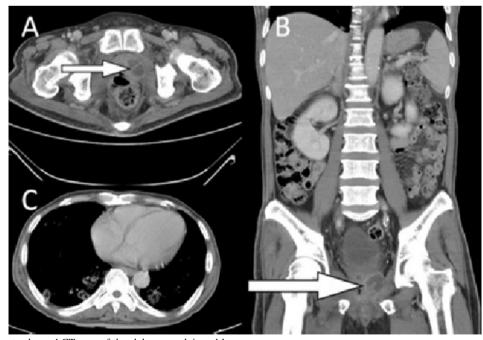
The contrast-enhanced CT scan of the abdomen, pelvis and lung. The axial view demonstrated that lobulated lesion of heterogeneous hypodensity (arrow in A). The coronal view demonstrated lobulated lesion of heterogeneous hypodensity (arrow in B) and no focal lesions within the parenchyma of liver, spleen, kidney and iliopsoas muscle. The axial view of CT scan the lung depicted multiple ring-enhanced lesions near bilateral pleural base with central cavitations consistent with septic pulmonary emboli complicating lung abscess (Panel C).
